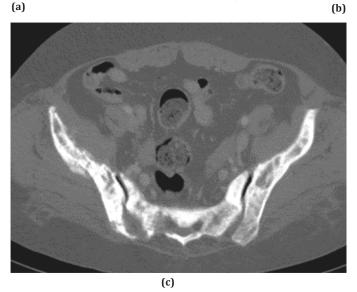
(a-c). Bone metastasis in breast cancer: Anteroposterior radiograph of the pelvis (a). Mixed metastatic lesions, blastic and lytic, are seen in a patient with disseminated breast cancer. Bone scan of the entire skeleton with multiple pathologic uptakes (b). Computed tomography (CT) image showing the metastatic lesions and pathologic fracture of the iliac bone (c).
